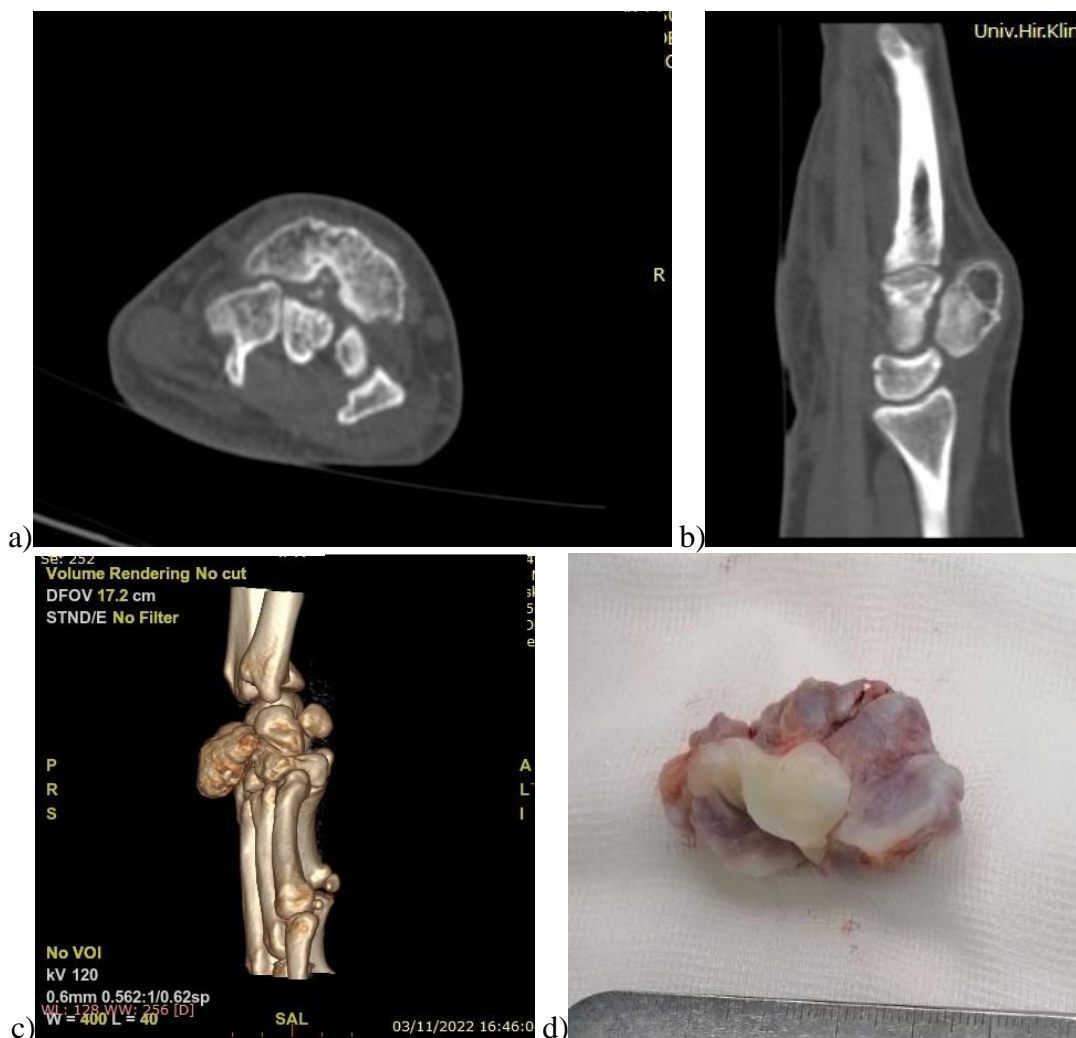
(a, b) CT scan of the right wrist. Axial and sagittal plane, revealing the presence of paraarticular chondroma, invading the carpal bones. c) CT 3D reconstruction of the wrist. d) Gross pathology of the removed tumor.
